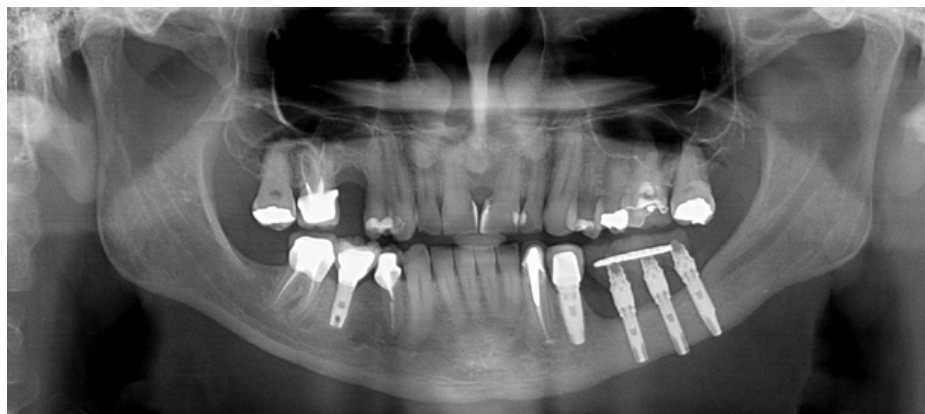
Panoramic radiograph showing the implants in excellent position after 2-years.
